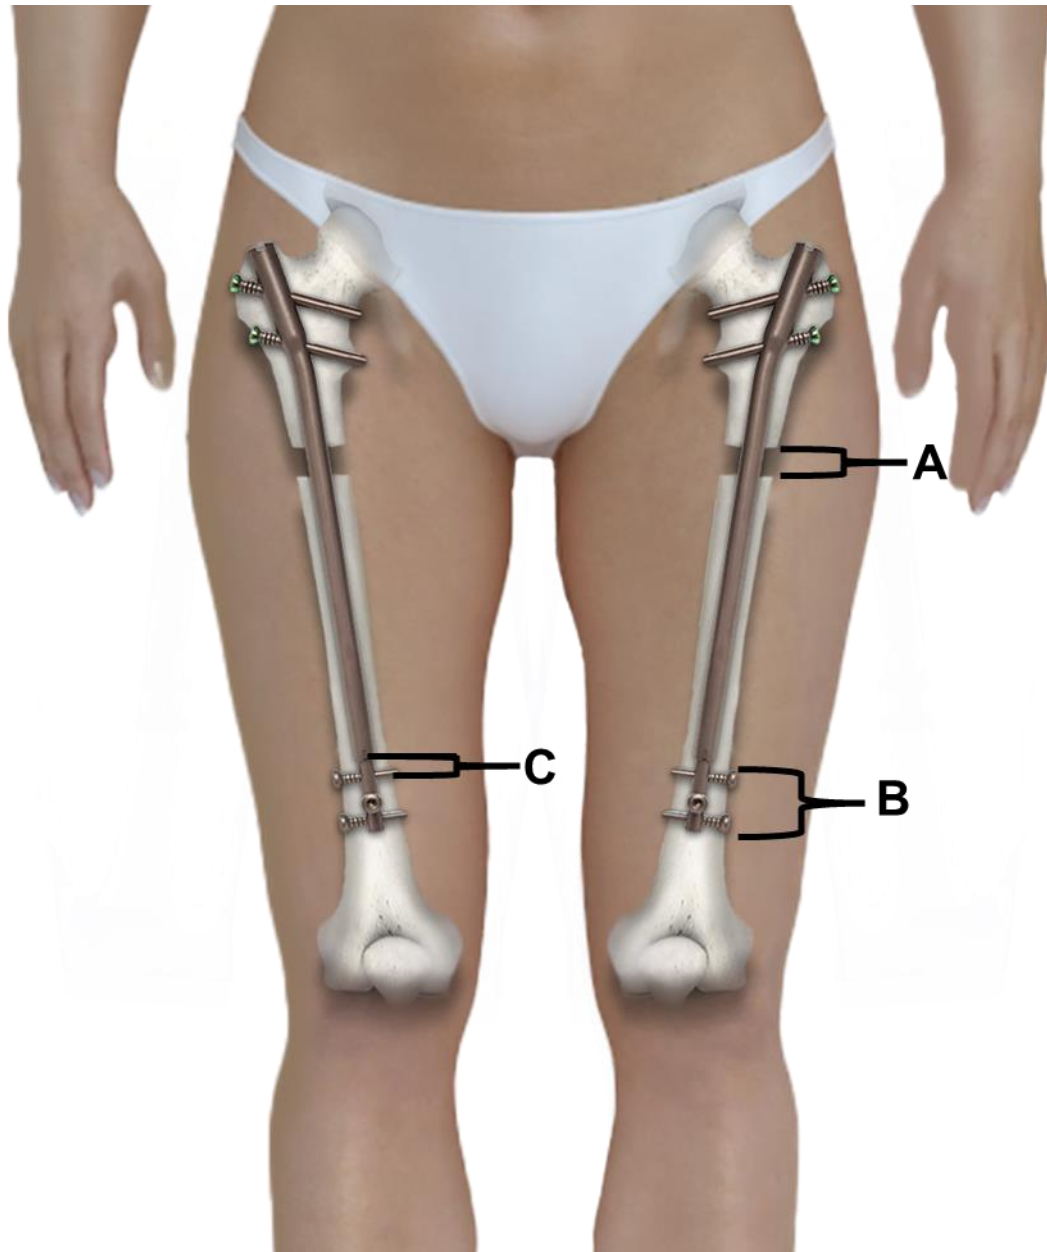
Femur areas of measuring on x-rays and ultrasound during lengthening
